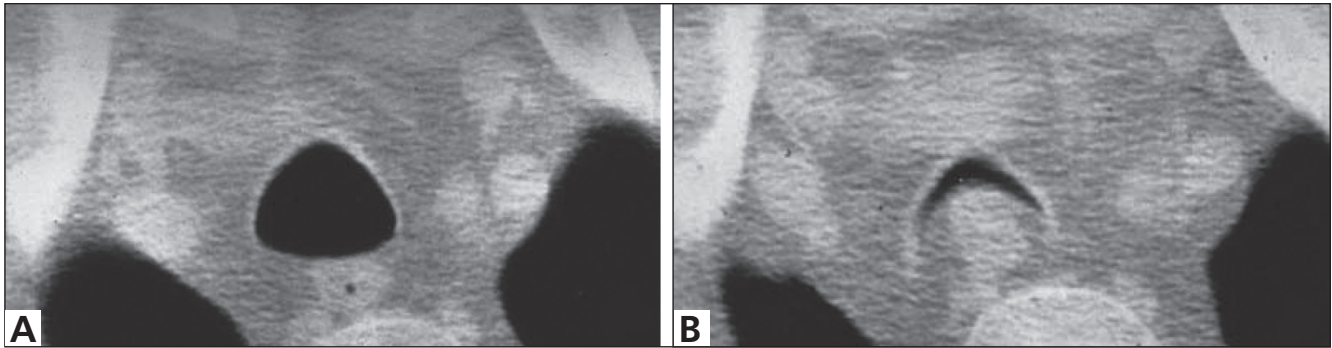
Findings of tracheomalacia in a dynamic respiratory CT. A. Inspiratory phase, B. Expiratory phase.
